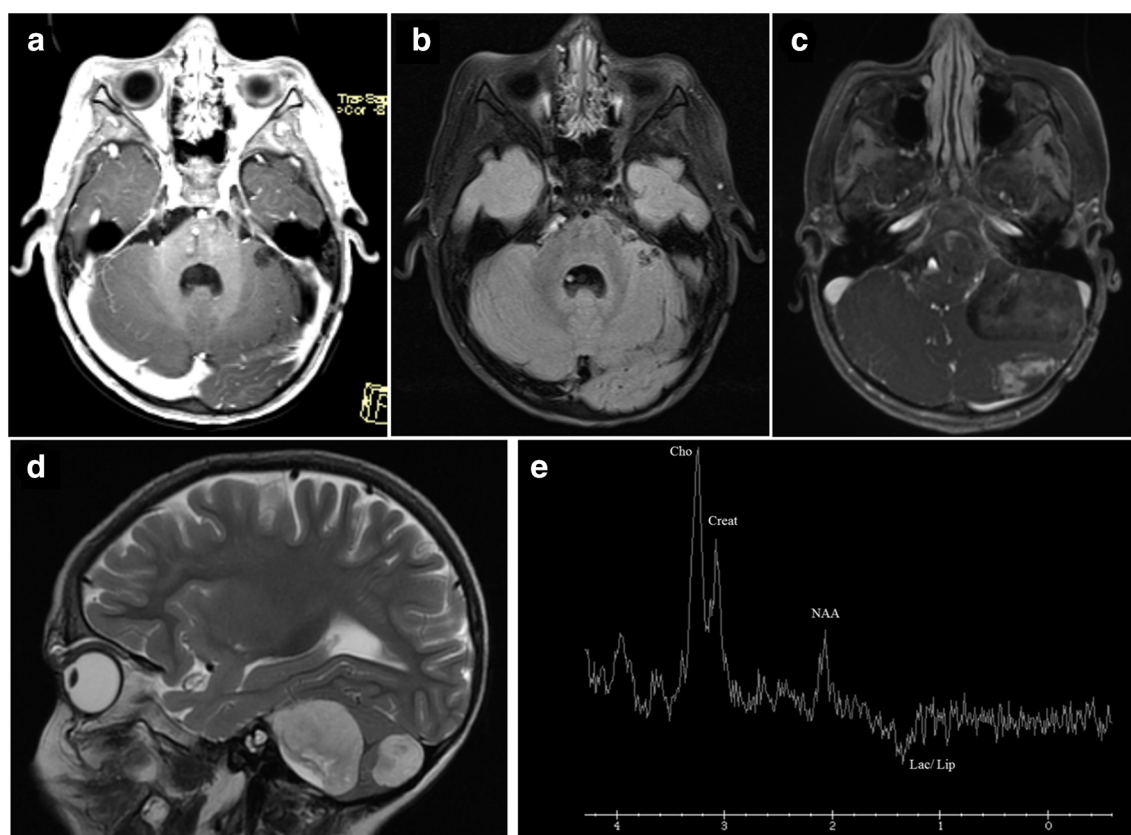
Axial T1 (a) and FLAIR MRI (b) showing the absence of recurrence at 19-month follow-up. The MRI performed 2 years later shows the last tumor relapse (c, axial T1 after gadolinium administration; d, sagittal T2), which appears as two apparently separate lesions, the largest one involving the surgical field in the cerebellopontine angle
